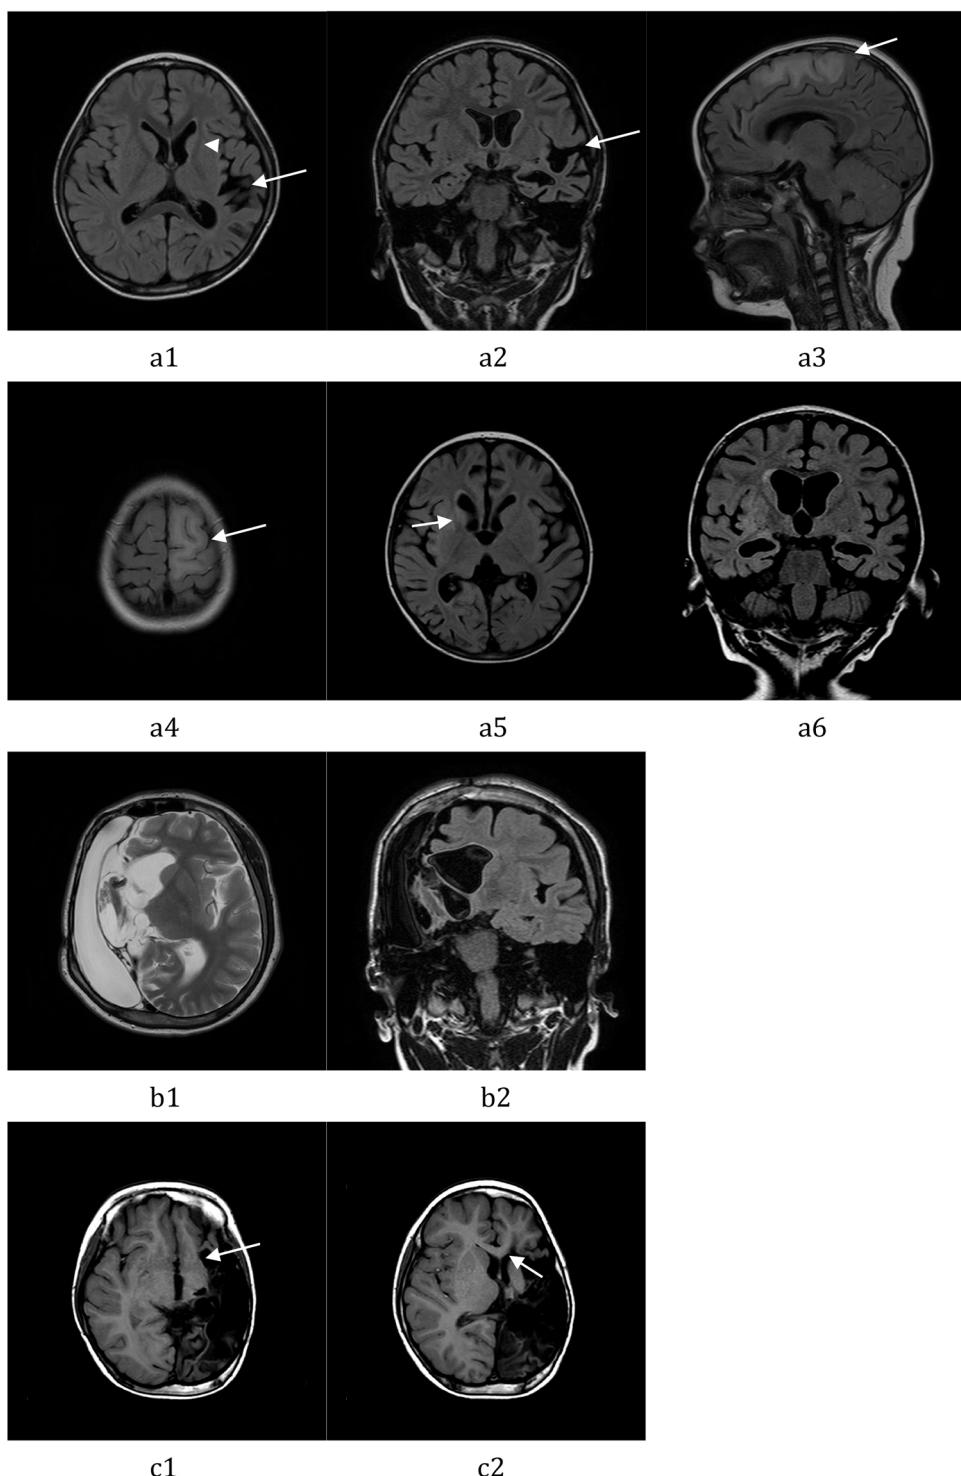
MRI before and after operation.
